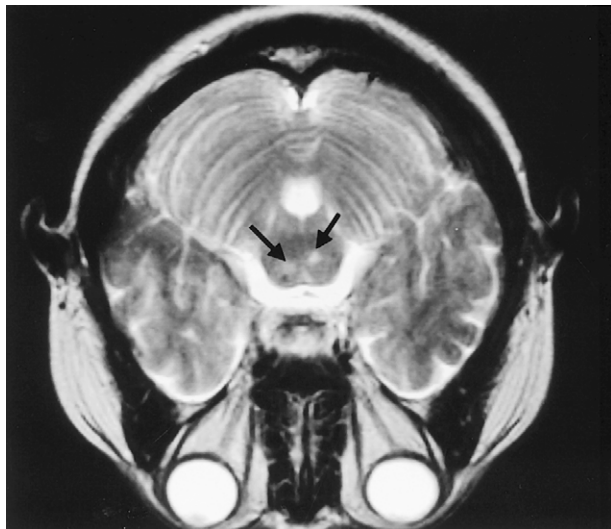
Magnetic resonance image from August 1997. T₂-weighted image at plane of transition between midbrain and pons in patient diagnosed as having neuro-Behçet's disease. Two high-intensity foci (arrows) are seen, indicating cerebral infarction.
